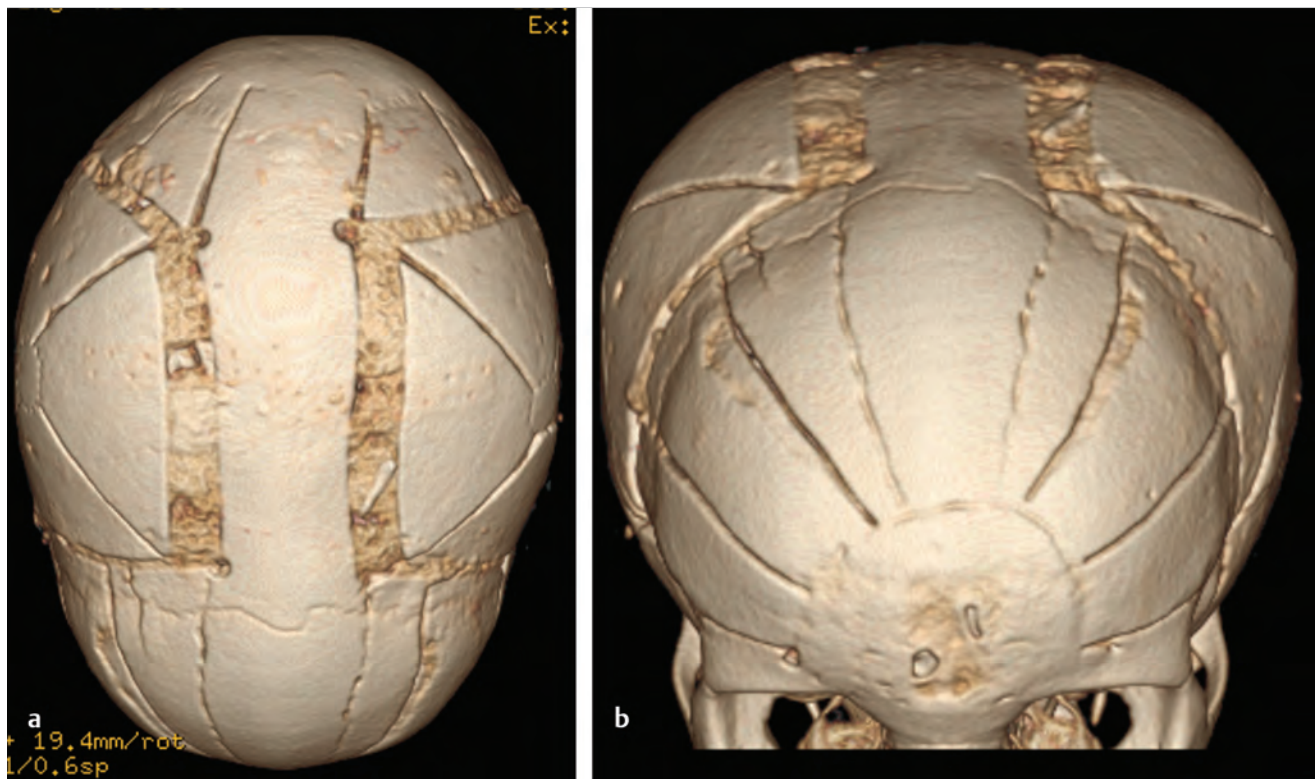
Postoperative CT after correction of sagittal synostosis. Each parietal segment was contoured, affixed to the out-fractured temporal bone, and stabilized in a more lateral position. There is a smooth transition between the contoured regions, and all osseous defects are filled with particulate bone graft.
